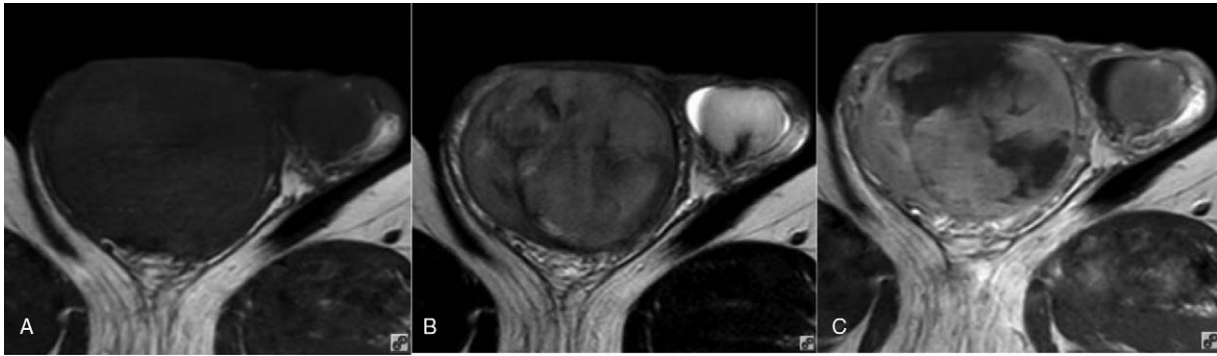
Fifty-six-year-old male with a large B-cell lymphoma. (A) Transverse T1WI showing a right testicular oval enlargement and an isointense signal; (B) transverse T2WI showing a hypointense signal; and (C) transverse T1WI+CE showing the septa were not enhanced. CE=contrast enhancement, T1WI=T1-weighted imaging, T2WI=T2-weighted imaging.
